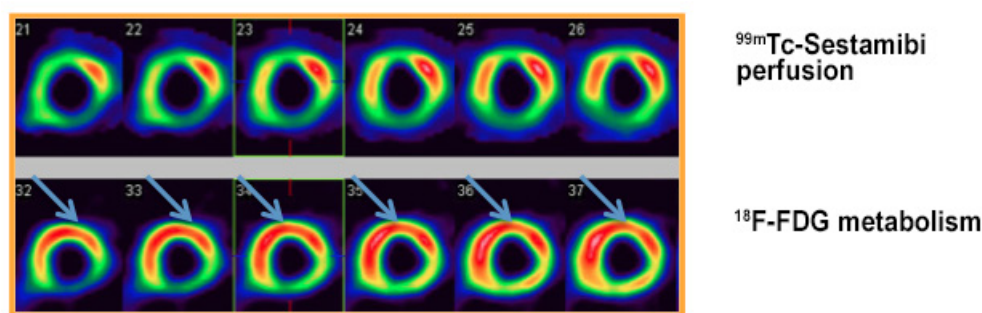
Myocardial perfusion scintigraphy with ^{99m}Tc -Sestamibi (upper line) and ^{18}F -FDG PET (lower line) for assessment of myocardial viability, showing improvement in perfusion/metabolism in anterior (apical, medial and basal), apical septal, anteroseptal (medial and basal) and inferoseptal (medial and basal) segments; “mismatch” pattern.
